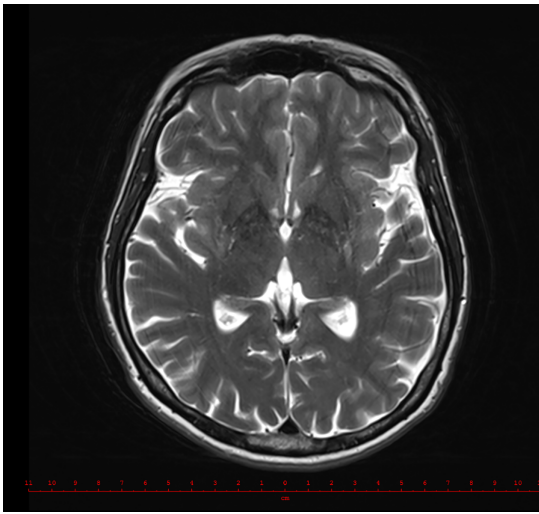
Brain MRI of case 1 (T₂-weighted turbo spin-echo [T₂ TSE]) showing very mild, bilaterally symmetric gliosis in the dorsal putamen without significant atrophy.
